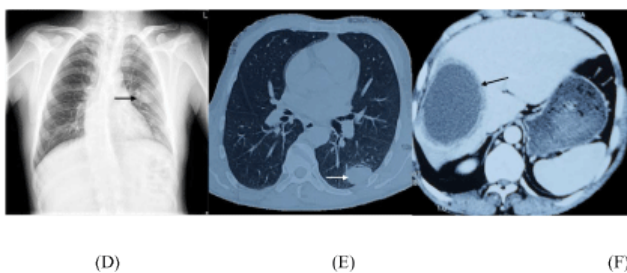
(D) Chest X-ray. (E) The lesion can be seen more clearly from the chest CT scan and air-fluid level exists in the cyst-like lesion. (F) A large cystic lesion with a rough rim can be figured out in the right liver lobe.
